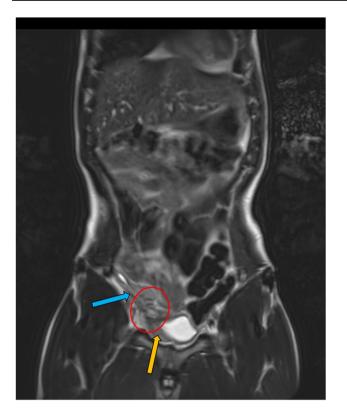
Preoperative coronal T2 SPACE MRI image of the patient's abdomen showing the inflammatory mass containing what was pre-operatively thought to be a urachus remnant but was confirmed intra-operatively to be an appendico-vesicular fistula (red circle); the appendix (blue arrow) adjacent to the inflammatory mass and bladder, which displays a thickened wall (yellow arrow)
